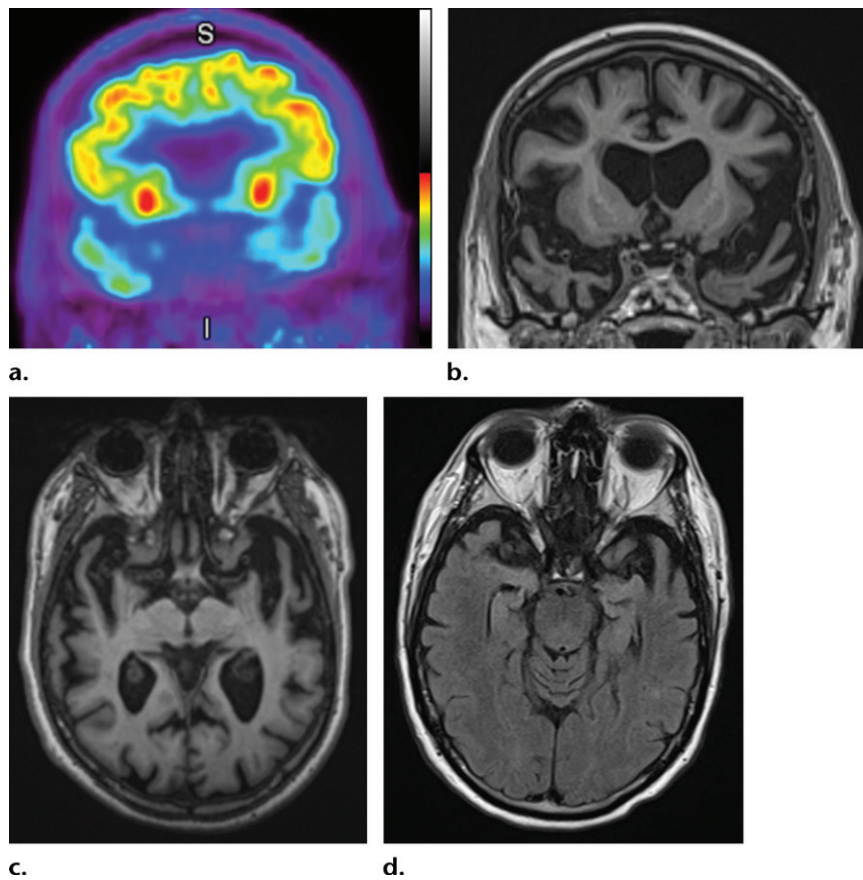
Frontotemporal lobar degeneration. (a) Coronal ^{18}F -FDG PET image at the level of the anterior temporal lobes shows markedly decreased temporal lobe uptake. *I* = inferior, *S* = superior. (b, c) Coronal (b) and axial (c) T1-weighted MR images show severe bilateral temporal lobe atrophy. (d) Axial MR image at the level of the temporal lobes obtained 5 years earlier demonstrates the significant progressive atrophy in this patient.
